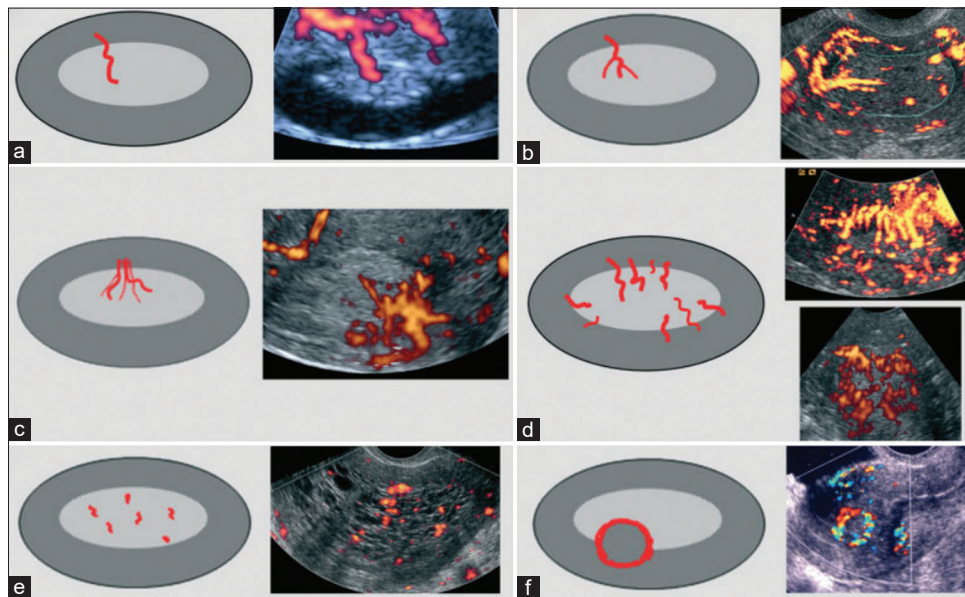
Vascular patterns on Doppler assessment based on the International Endometrial Tumor Analysis consensus statement^[6] (a) Single dominant vessel without branching (b) Single dominant vessel with branching (c) Multiple vessels with focal origin (d) Multiple vessels with multifocal origin (e) Scattered vessels without visible origin (f) Circular flow
